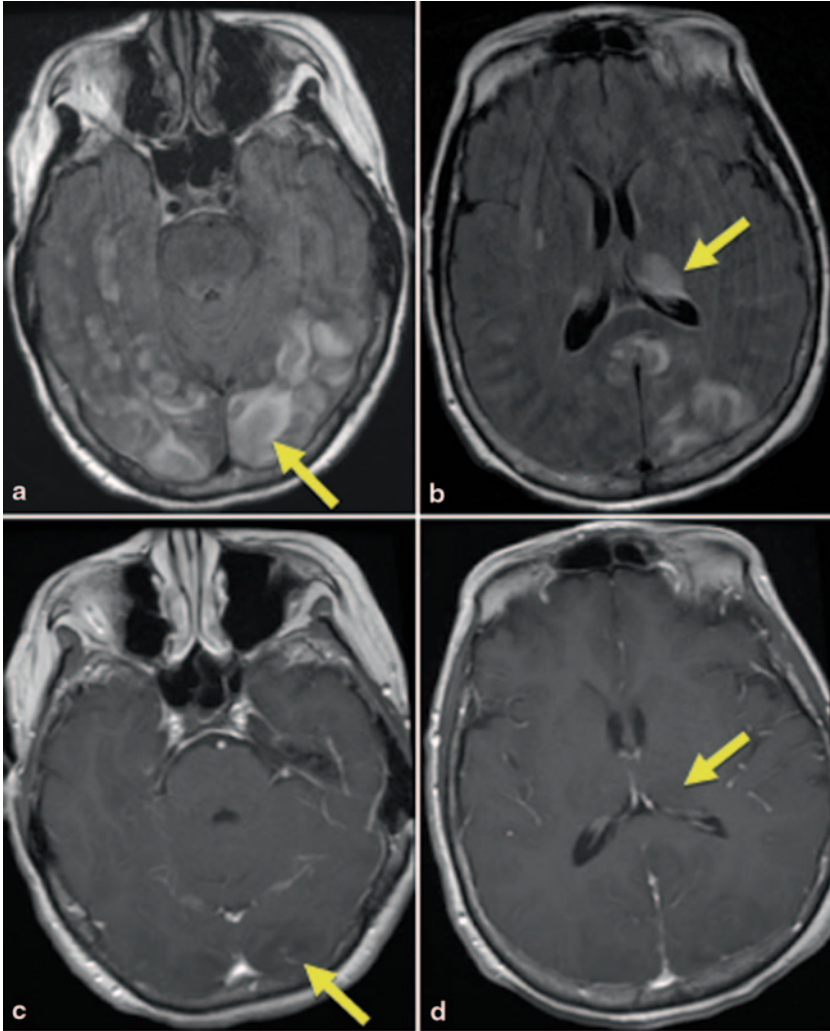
Axial MRI images of PRES with multiple areas of T2/FLAIR (a, b) hyperintensity involving the white matter of the occipital lobes and thalamus (arrows) and correlating minimal T1-contrast enhancing (arrows) (c, d) in a 60-year-old woman with depressed consciousness, hypertension, fever, day 216 after reduced intensity allogeneic HSCT
